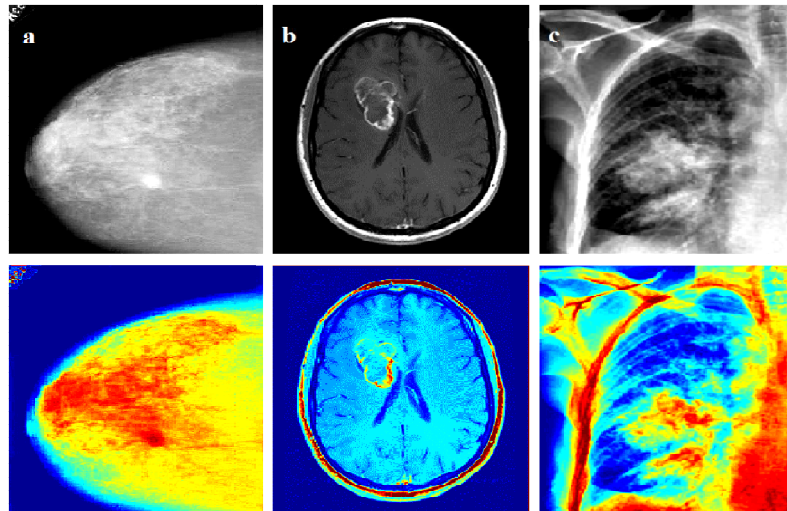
On the top row there are images of (a) a mammogram, (b) a MR brain tumor, and (c) a lung cancer CT image. The DWT algorithm is implemented on all of images and is shown results on the bottom row
